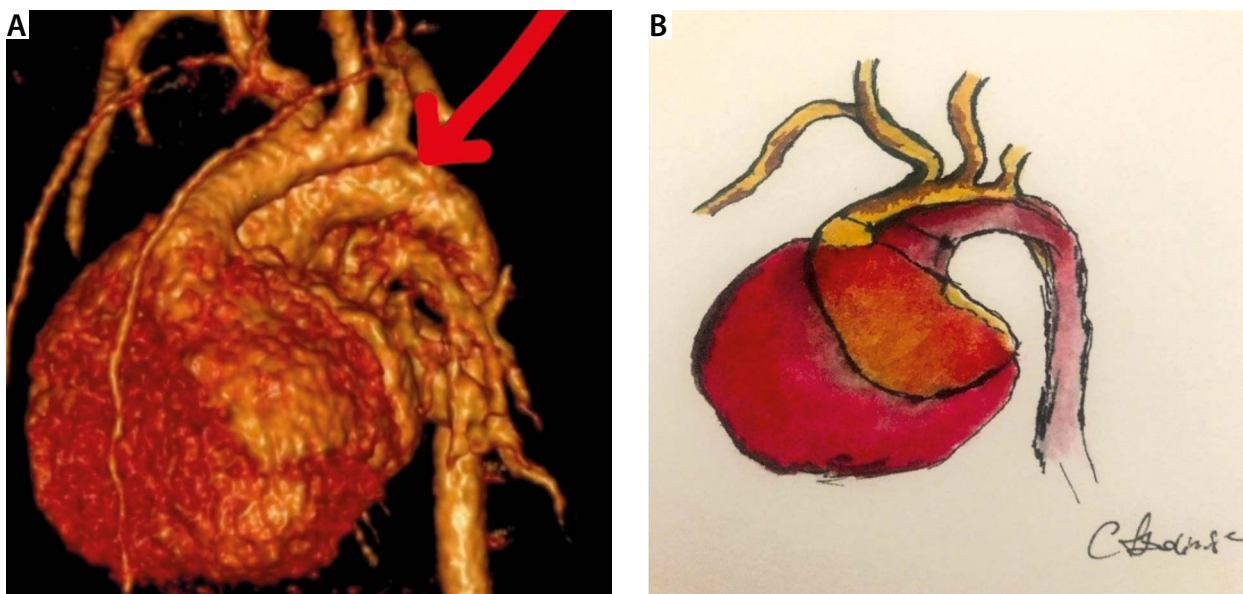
Postnatal confirmation. A – Newborn volume-rendered computed tomography angiography on the 5th day of postnatal life: the hypoplastic right ventricle/left ventricle are in a superior-inferior relation to each other due to an abnormal ventricular rotation in the criss-cross heart malformation. The aorta (indicated by an arrow) in front emerges from the upper chamber, which is a hypoplastic right ventricle: ventriculo-arterial discordance. The red arrow is pointing at coarctation of the aorta. B – A graphic assessment by AZ
